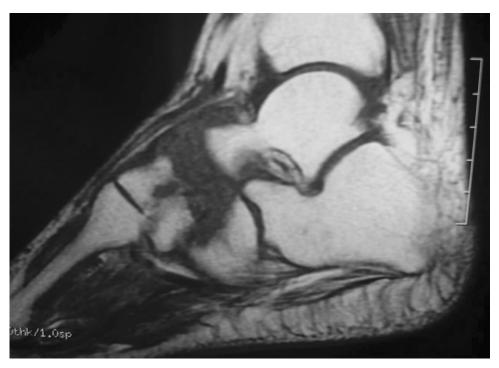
The MRI of the patient showed a diffuse low-intensity signal on T1-weighted sagittal image in the left navicular bone.
